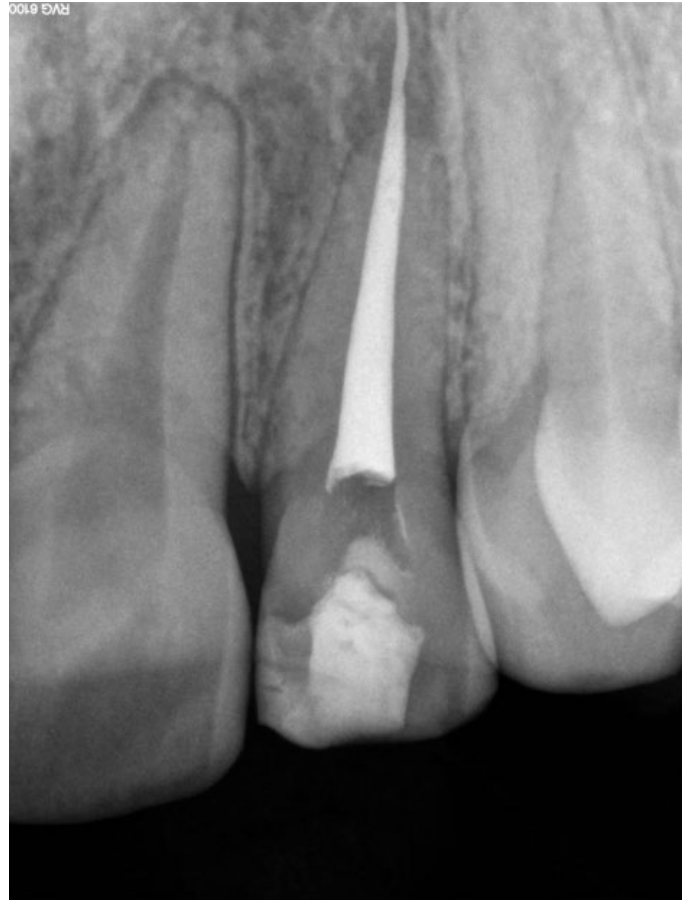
(B) Periapical image demonstrating radiographic LEO.
